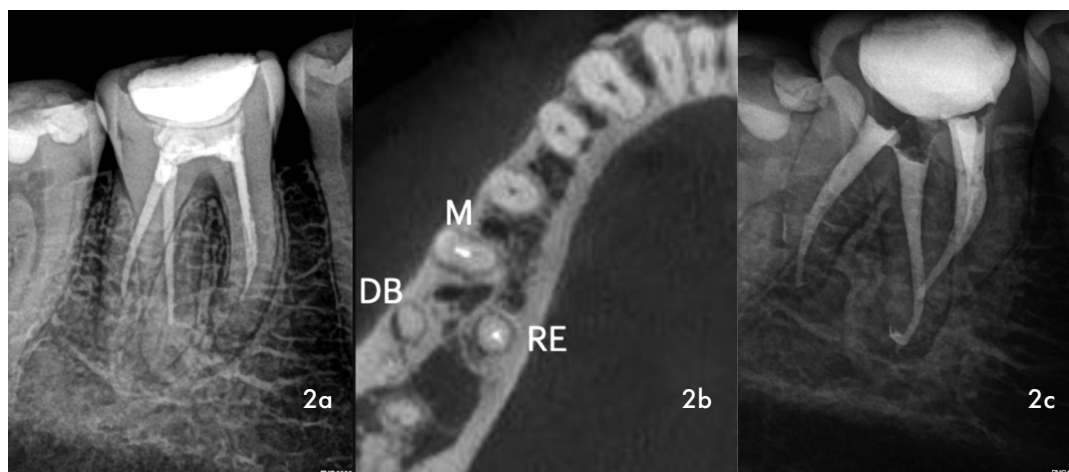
(a) Pre-operative radiograph of mandibular, right first permanent molar that was poorly root treated 2 years previously (b) CBCT- midroot axial view shows the presence of a mesial root (M), distal (D) and Radix Entomolaris on the lingual aspect (RE) (c) A 30 degrees, mesial angulated view of four obturated root canal systems.
